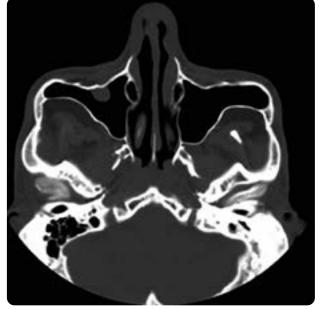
Bone window CT scan of a patient with acromegaly: an increase in the diameter of the maxillary sinuses is observed and, additionally, on the right, a polyp. These are frequent findings in patients with acromegaly associated with hyperpneumatization of the sinuses.
